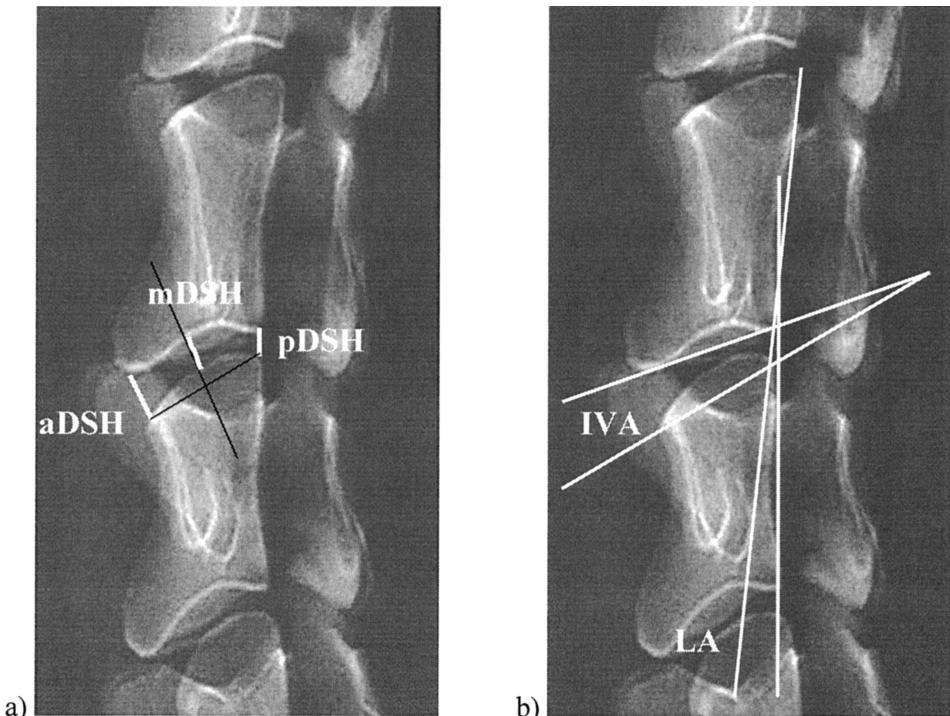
Radiographic measurements. a, Anterior disc space height (aDSH), posterior disc space height (pDSH), and middle disc space height (mDSH); b, intervertebral angle (IVA) and lordosis angle (LA).
